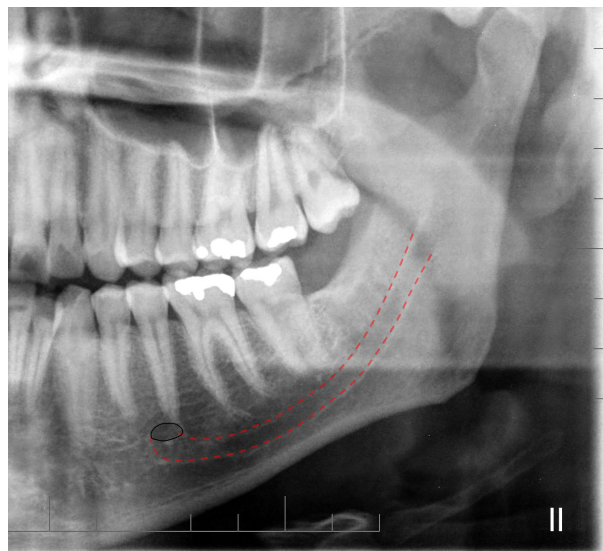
Radiographic image of the mandibular canal type 2 (red traces) in relation to the lower molars apices according Nortjé et al. (10) classification.
